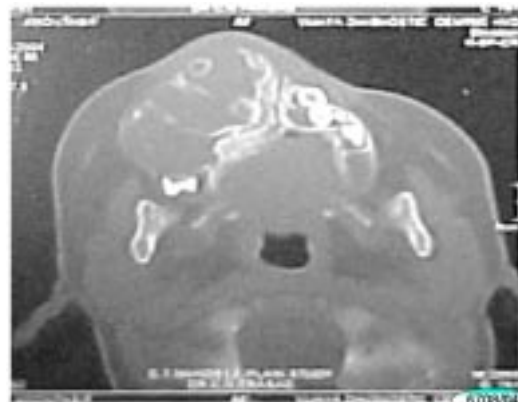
Axial CT (bone window) showing osteolytic lesion involving the maxilla with soft tissue component
